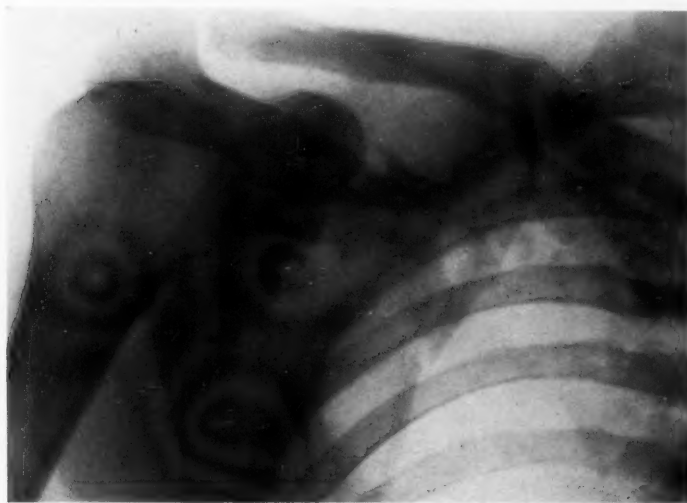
X-ray of Case IV. Note displacement and lines of fracture through the body and spine of scapula.
